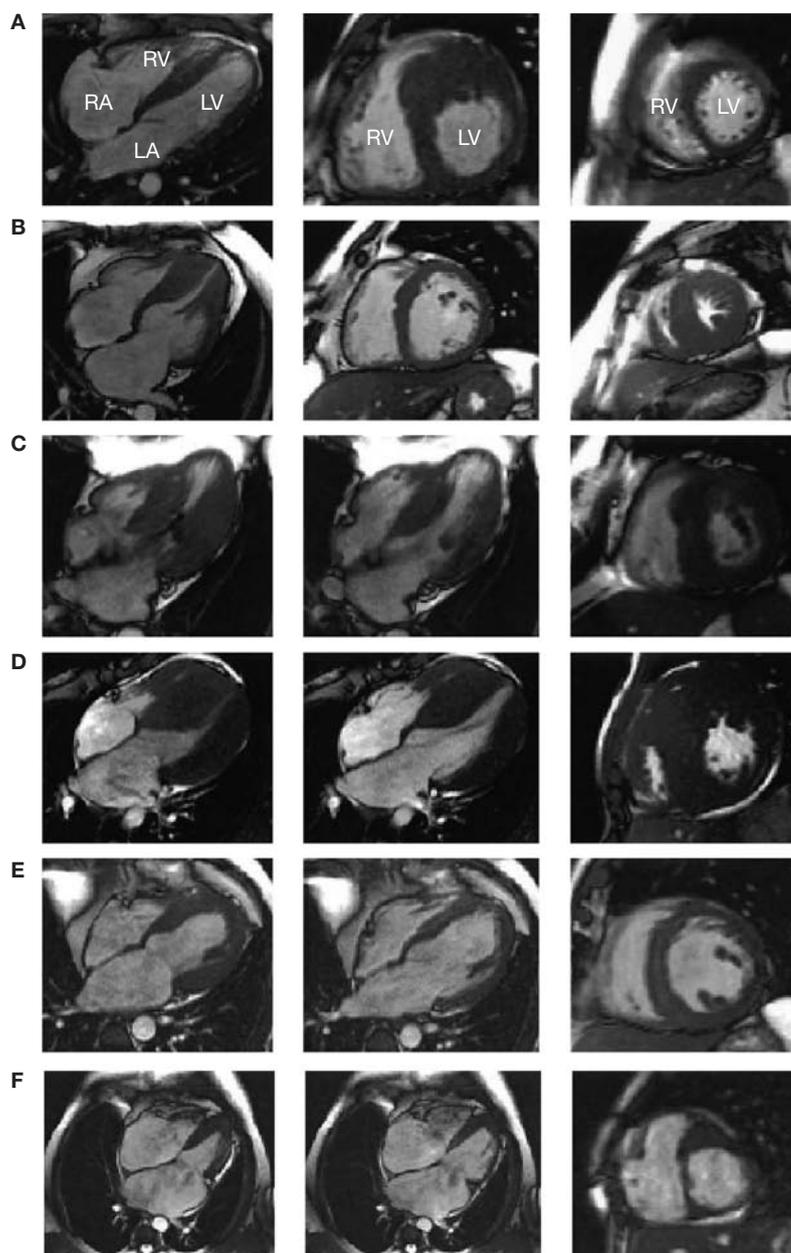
Cine cardiac MRI of hypertrophic cardiomyopathy patients with troponin I mutations. (A) Asymmetrical anteroseptal hypertrophy (Arg162Gln); (B) apical hypertrophy (Arg162Gln); (C) midcavity obstruction (Arg145Trp); (D) extreme biventricular hypertrophy (Arg141Gln); (E) ‘end-stage’ dilation (Arg186Gln); and (F) restrictive cardiomyopathy in a child 6 years of age (*de novo* Lys178Glu). (A and B) All images were captured during diastole; left-hand images show the four-chamber view, the central images show the cross-sectional view at the papillary muscle level, and the right-hand images show cross-sectional view at the apical level. (C to F) The left-hand images show the four-chamber view, captured during systole, the central images show the four-chamber view during diastole, and the right-hand images show the cross-sectional view at the papillary muscle level. Abbreviations: LA, left atrium; LV, left ventricle; RA, right atrium; RV, right ventricle. This figure was published in *Journal of the American College of Cardiology* Mogensen J *et al.* Frequency and clinical expression of cardiac troponin I mutations in 748 consecutive families with hypertrophic cardiomyopathy 44: 2315–2325 © Elsevier (2004).
